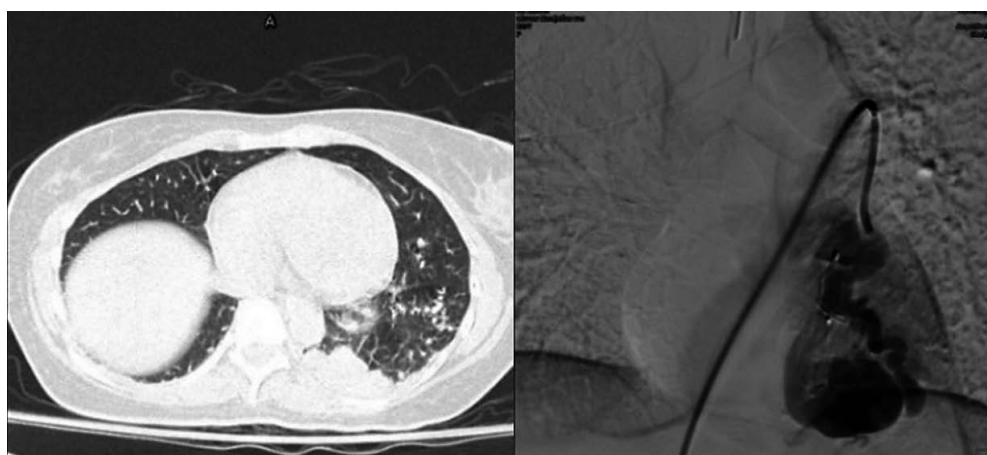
Left, CT angiogram of chest demonstrated abnormal dilated vascular structure in the left basal lung. Right; Angiographic study showed arteriovenous malformations in the left lung.
